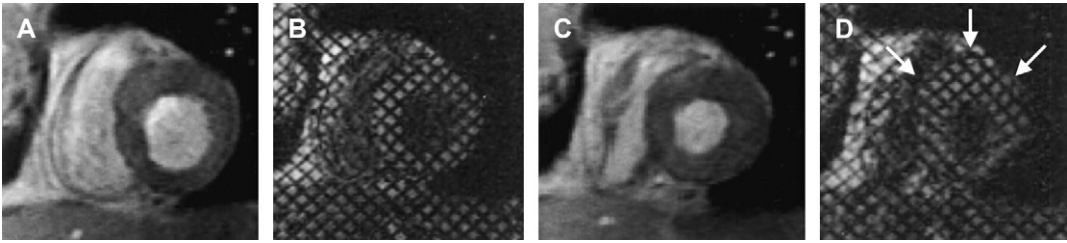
Tagging of the left ventricle. Images of a patient without (A) and with (B) tagging during the diastolic phase of a normal left ventricle at rest. (C, D) are comparative images at peak stress. There is akinesia of the anterior, anterior-septal, and septal walls indicating ischemia. (From Wahl A, Paetsch I, Roethemeyer S, et al. High-dose dobutamine-atropine stress cardiovascular MR imaging after coronary revascularization in patients with wall motion abnormalities at rest. *Radiology* 2004;233:210–6; with permission.)
